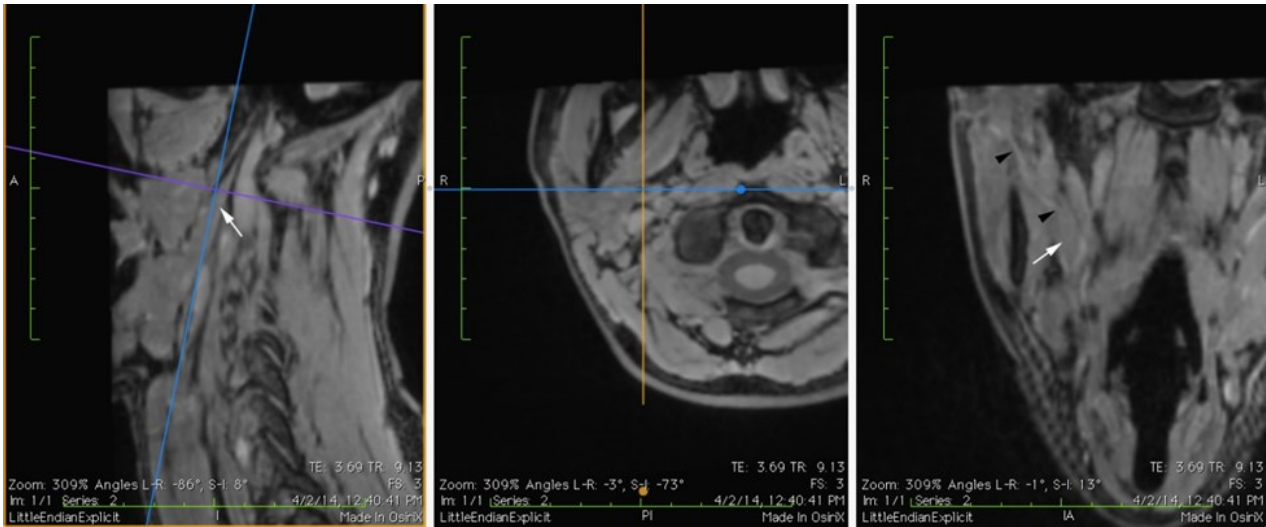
FLASH 3D T1 fat-suppressed MRI images of the styloid process (left and center panels under the axes), stylopharyngeus muscle (white arrow) and glossopharyngeal nerve and its innervation point of the muscle (black arrowheads). The blue axis on the left panel corresponds to the image in the left panel. The purple axis in the left panel corresponds to the image in the center panel.
